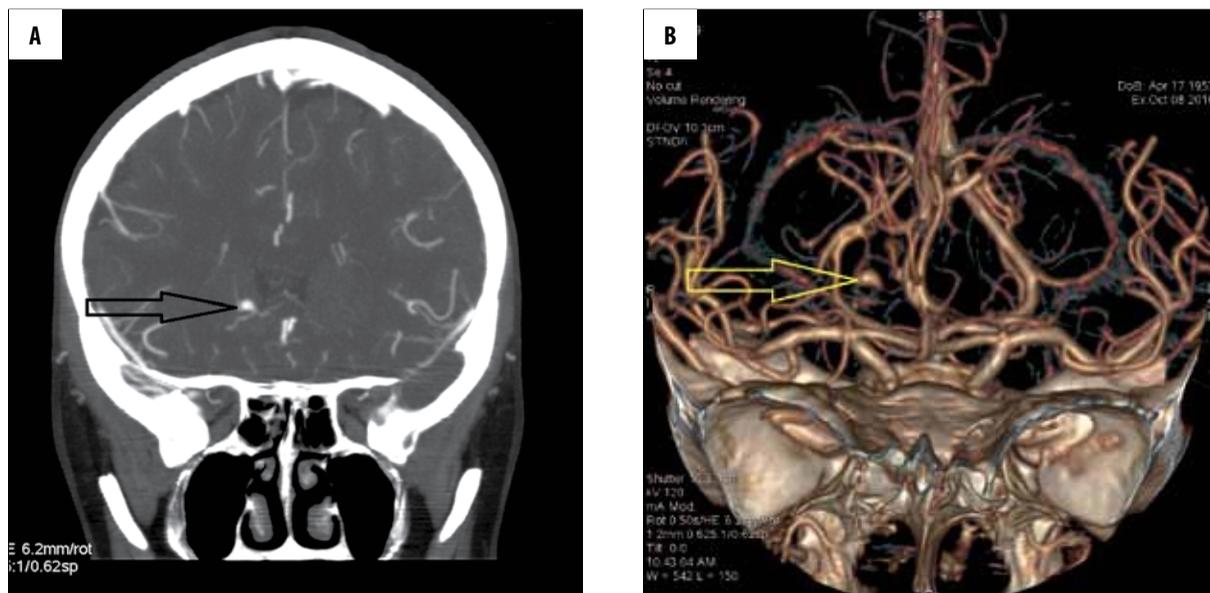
CT angiography. (A) MIP image – coronal plane, (B) 3D reconstruction – retention of contrast medium in cavernous hemangioma (arrow).
